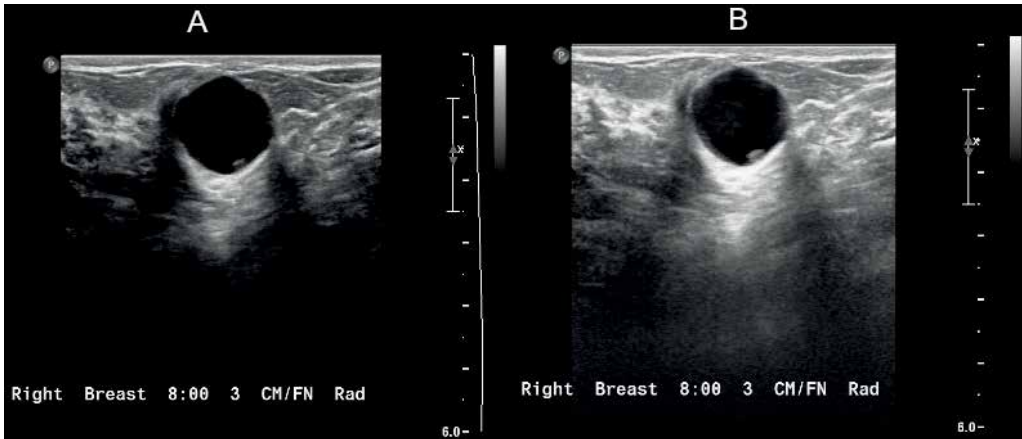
Harmonics reduce artefactual echoes. Transverse ultrasound of the right breast shows harmonics reducing artefactual echoes. (A) With harmonics and (B) without harmonics.
